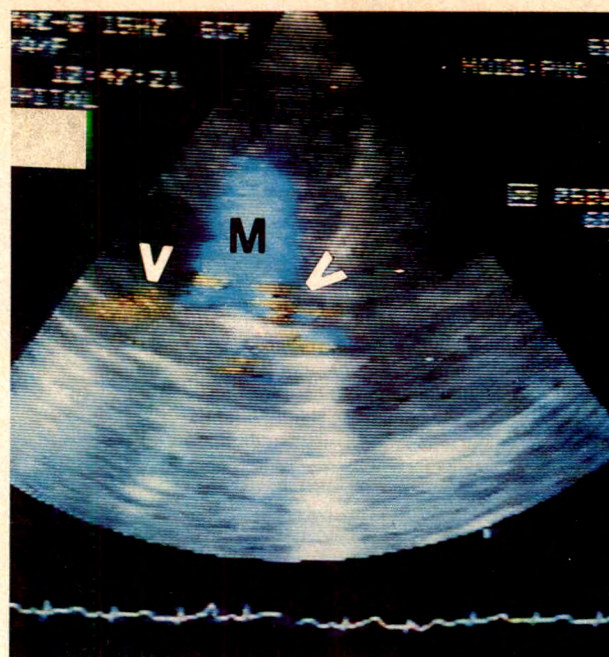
The 2-dimensional color echocardiogram was recorded from an infant with peripheral pulmonary stenosis during late ventricular systole and displays a low velocity uniform flow pattern in the main (M) pulmonary artery and aliasing in the branch right and left (R and L) pulmonary arteries. Note also the small caliber of the branch pulmonary arteries compared with the main pulmonary artery. (Arrowheads highlight the origin of the pulmonary artery branches.)
